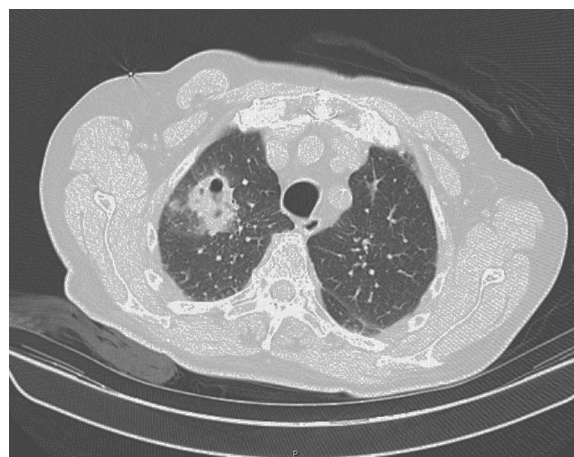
Computed tomography (CT) showing solitary pulmonary lesion in the upper right lobe. The lesion has irregular boundaries and a caveated component is exhibited.
